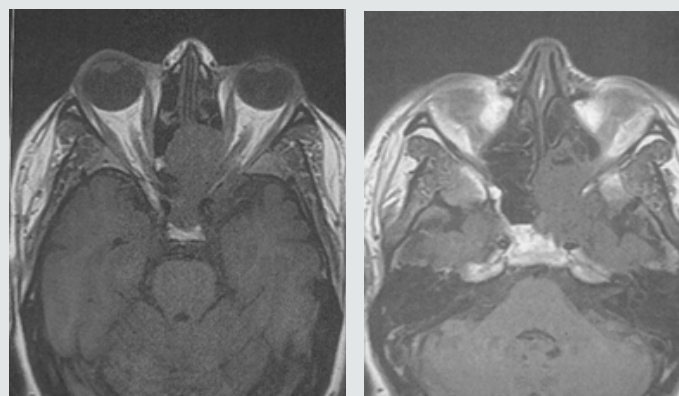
& Figure 1B: Axial T1 weighted MRI sequence images: mass of the left sphenoid sinus with an extension to the cavernous sinus and the ethmoid bone that compresses the left optic nerve.
